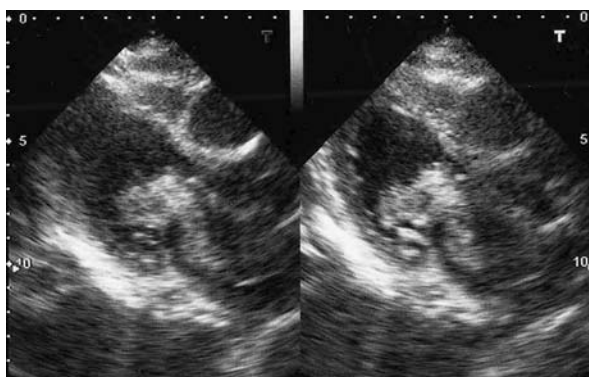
Diagnostic echocardiography shows the left atrial tumor and mitral valve obstruction.
